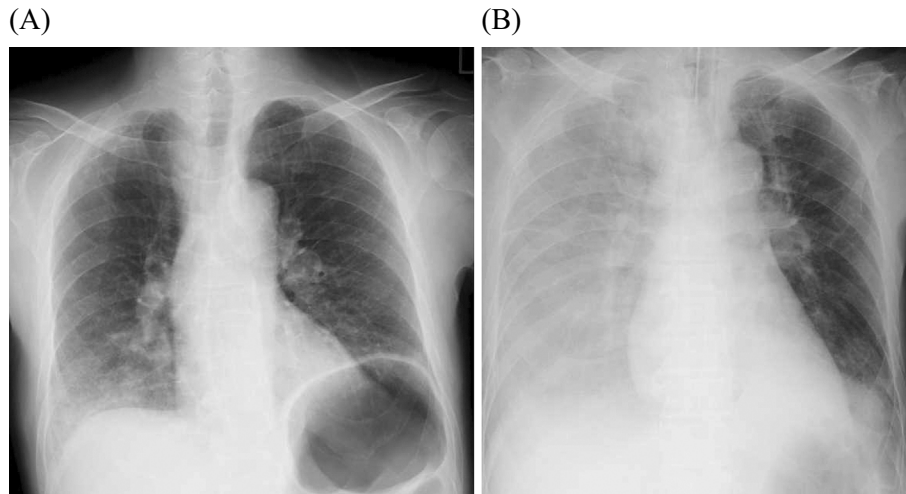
(A) Chest X-ray showed a consolidation in the right lower lung field at the time of admission. (B) The consolidation rapidly worsened and developed in both lungs on Day 4 of hospitalization.
